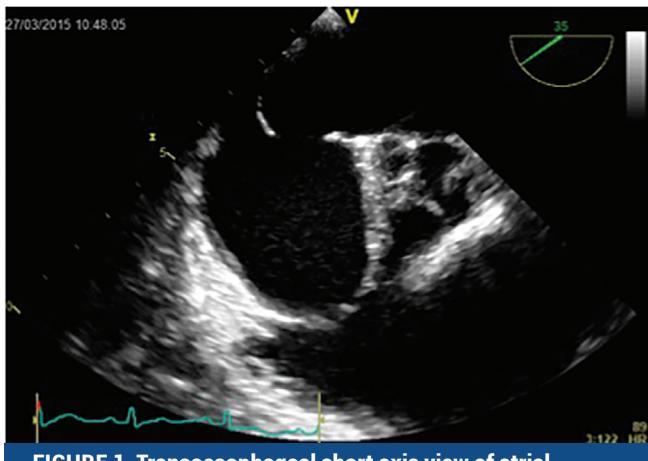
Transoesophageal short axis view of atrial septal defect.
